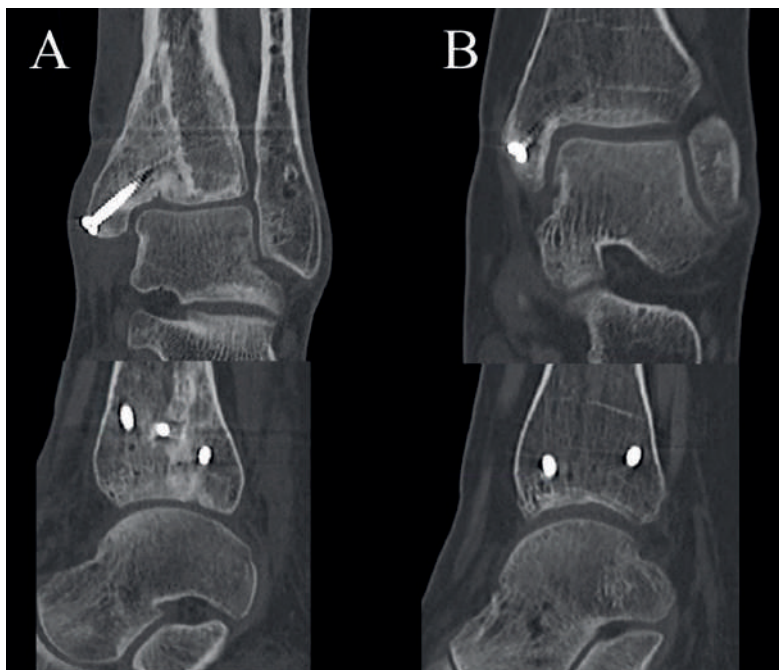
1-year and 3-year postoperative CT-scan of the cases in figure 1 and figure 2, respectively.
